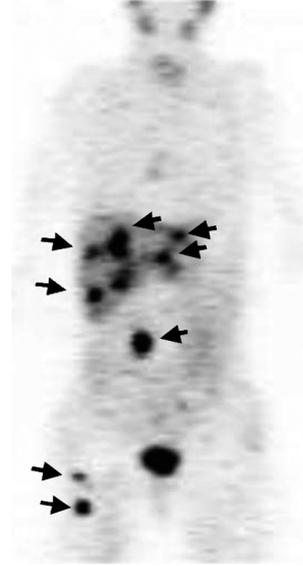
Iodine-labeled metaiodobenzylguanidine scintigraphy revealed an intense accumulation in the right abdomen, multiple intense accumulations in the liver and right femur, and multiple moderate accumulations in the thoracic and lumbar spine.
